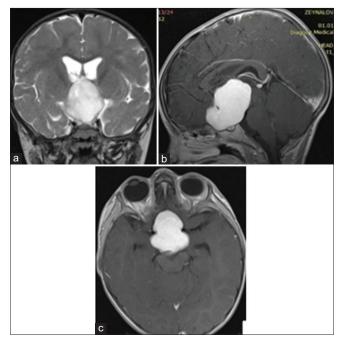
Preoperative magnetic resonance image: (a) T2-weighted image (coronal section) demonstrates hyperintense mass localized in the sella and extending to the suprasellar area, compressing the third ventricle. (b) T1-weighted image (B: sagittal), a contrastenhanced image of the brain showing homogenous enhancement of the lesion. (c) T1-weighted image (axial section), contrast-enhanced image showing homogenous enhancement of the mass.
